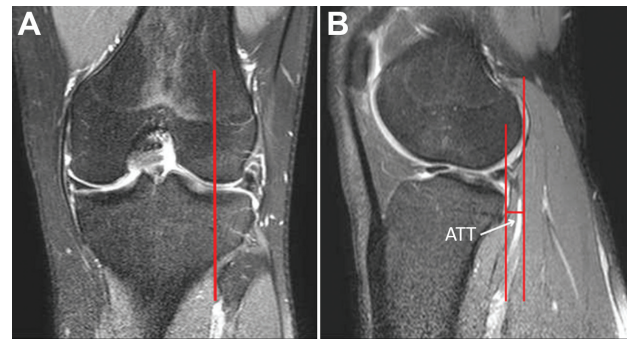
ATT was measured using proton density-weighted MRI sequences. (A) The midsagittal plane of the lateral femoral condyle (red line) was identified on coronal images. (B) Two vertical lines were drawn from the posterior aspects of the subchondral bone of the lateral femoral condyle and lateral tibial condyle. The shortest distance between the 2 vertical lines was considered the ATT. ATT, anterior tibial translation; MRI, magnetic resonance imaging.
